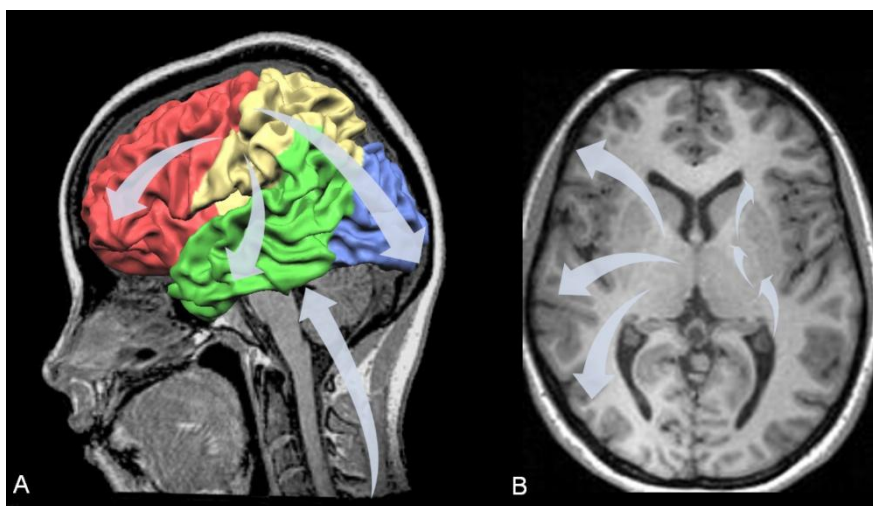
MRI of the brain depicts the progression of myelination. (A) Myelination progressing in a caudocranial direction from the brain stem, through the posterior limb of internal capsule and to the hemispheric white matter, proceeding to the central sulcus toward the poles. (B) Myelination advancing from deep to superficial and from posterior to anterior (Modified from Ballesteros *et al.*, 1993).
